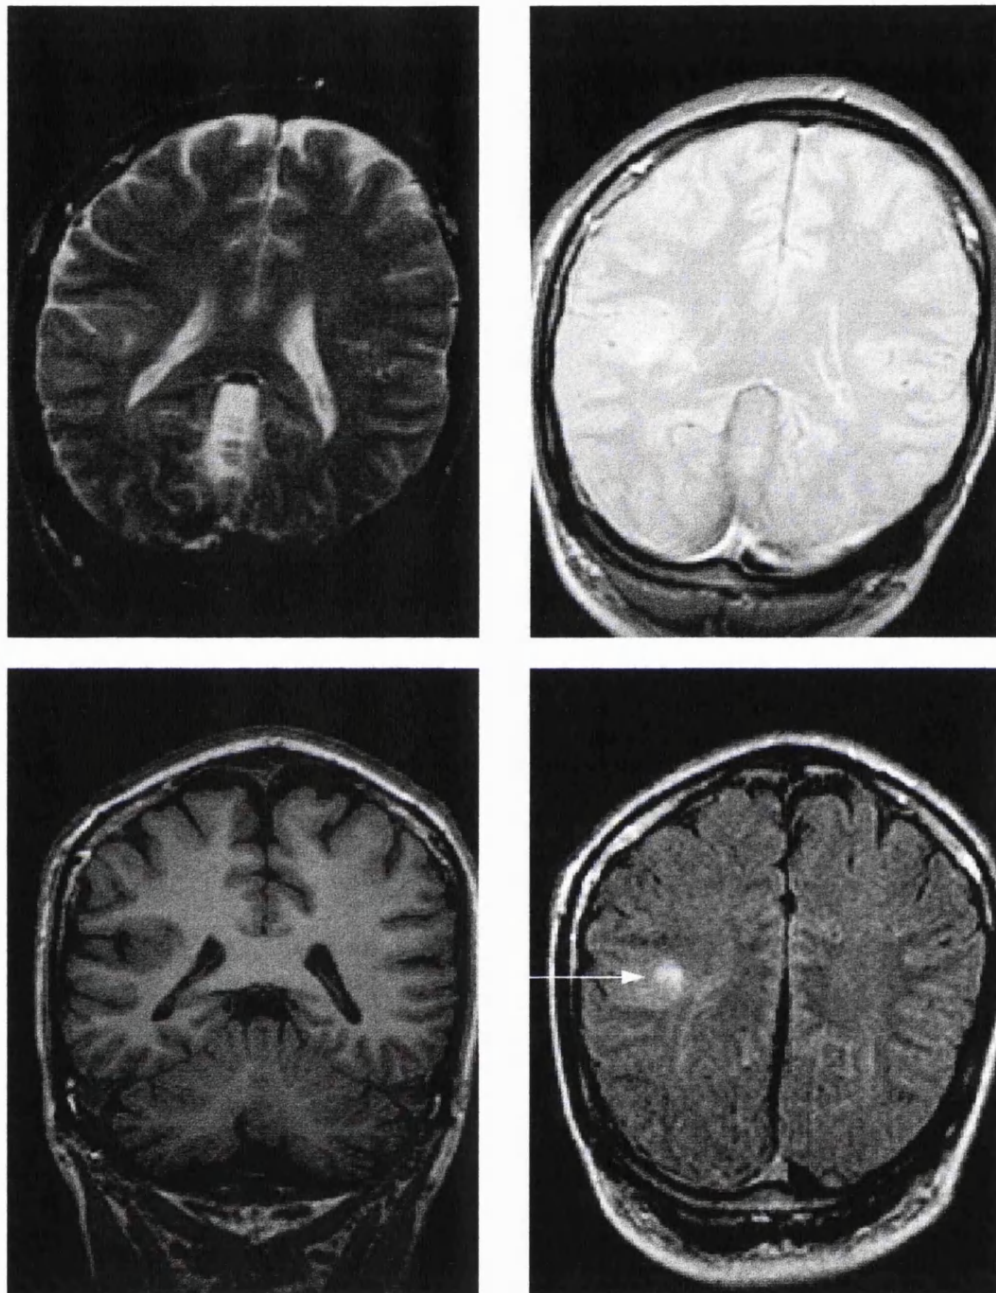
Presumed DNT. Coronal spin echo T2-weighted image (top left), proton density weighted image (top right), T1-weighted image (bottom left) and fast FLAIR image (bottom right). A small cortical mass is shown in the right posterior temporal lobe. The signal intensity change is most conspicuous on fast FLAIR. The patient had partial epilepsy.
